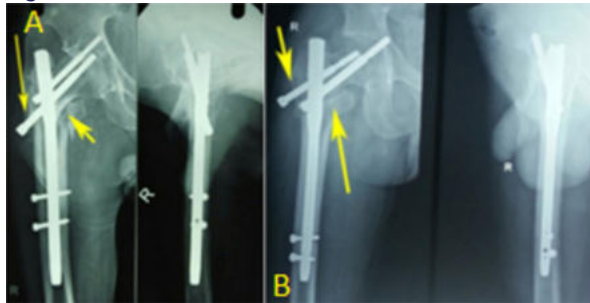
Modes of failure after internal fixation of intertrochanteric fractures. Post operative radiographs showing varus collapse with migration of screws as Z effect (figure A) and reverse Z effect (figure B)
